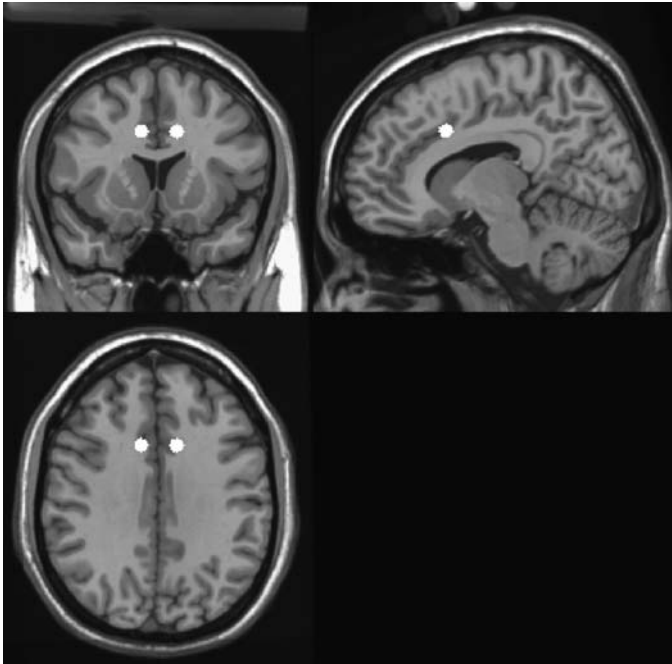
Typical locations of anterior cingulotomy lesions superimposed upon normalized T1 MRI scan. Lesions not to scale.
